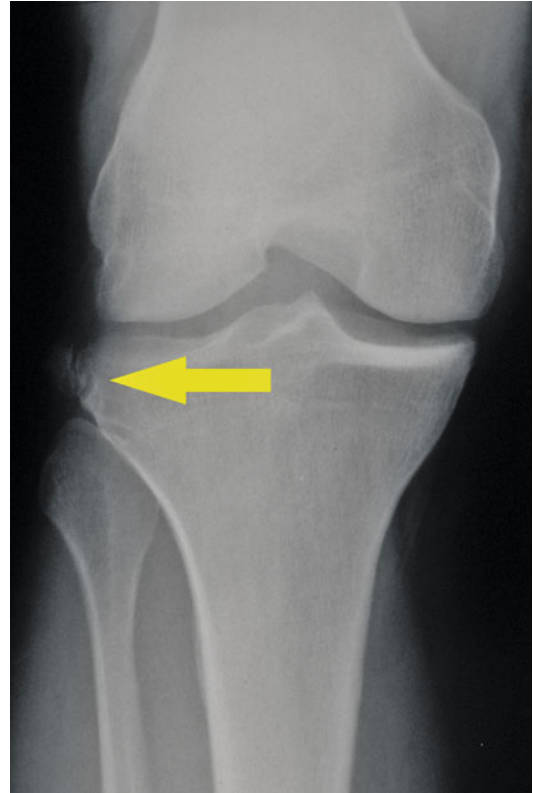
Radiograph of a right knee demonstrating a Segond fracture of the tibial condyle (yellow arrow)
